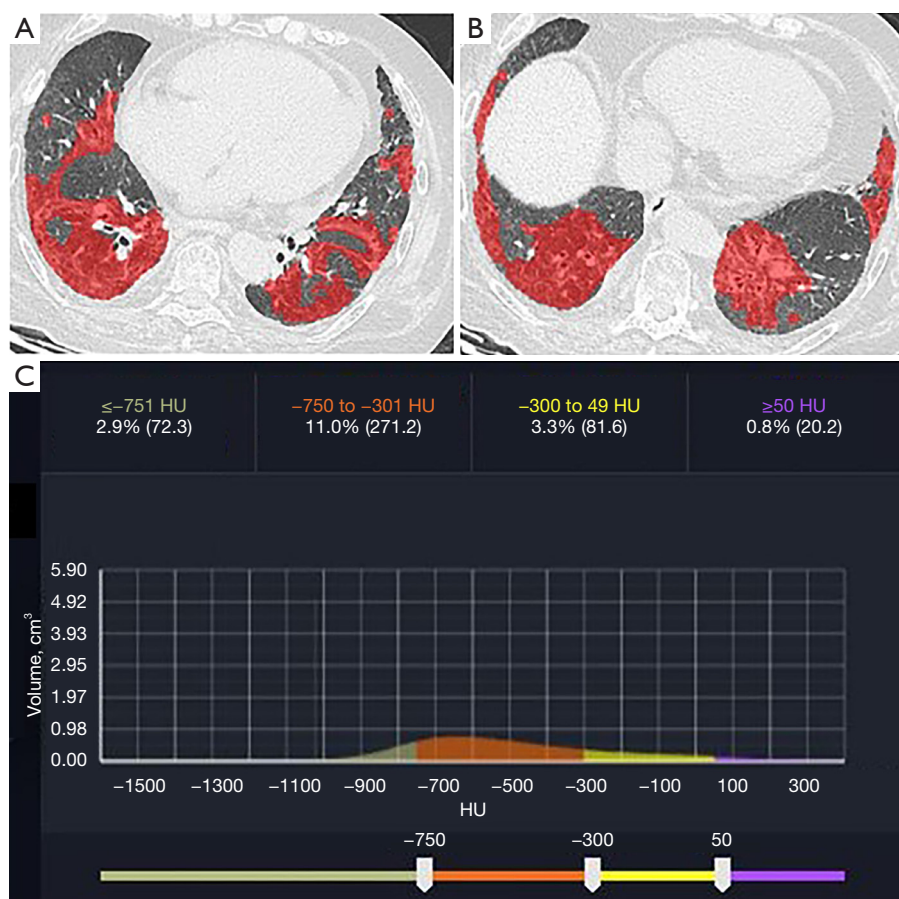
Representative AI images. A 75-year-old male patient with CTD-ILD. (A,B) Two HRCT slices, with the red regions indicating lung lesions automatically identified by AI. (C) A histogram of CT values from the lung lesions. AI, artificial intelligence; CT, computed tomography; CTD-ILD, connective tissue disease-associated interstitial lung disease; HRCT, high-resolution computed tomography; HU, Hounsfield units.
